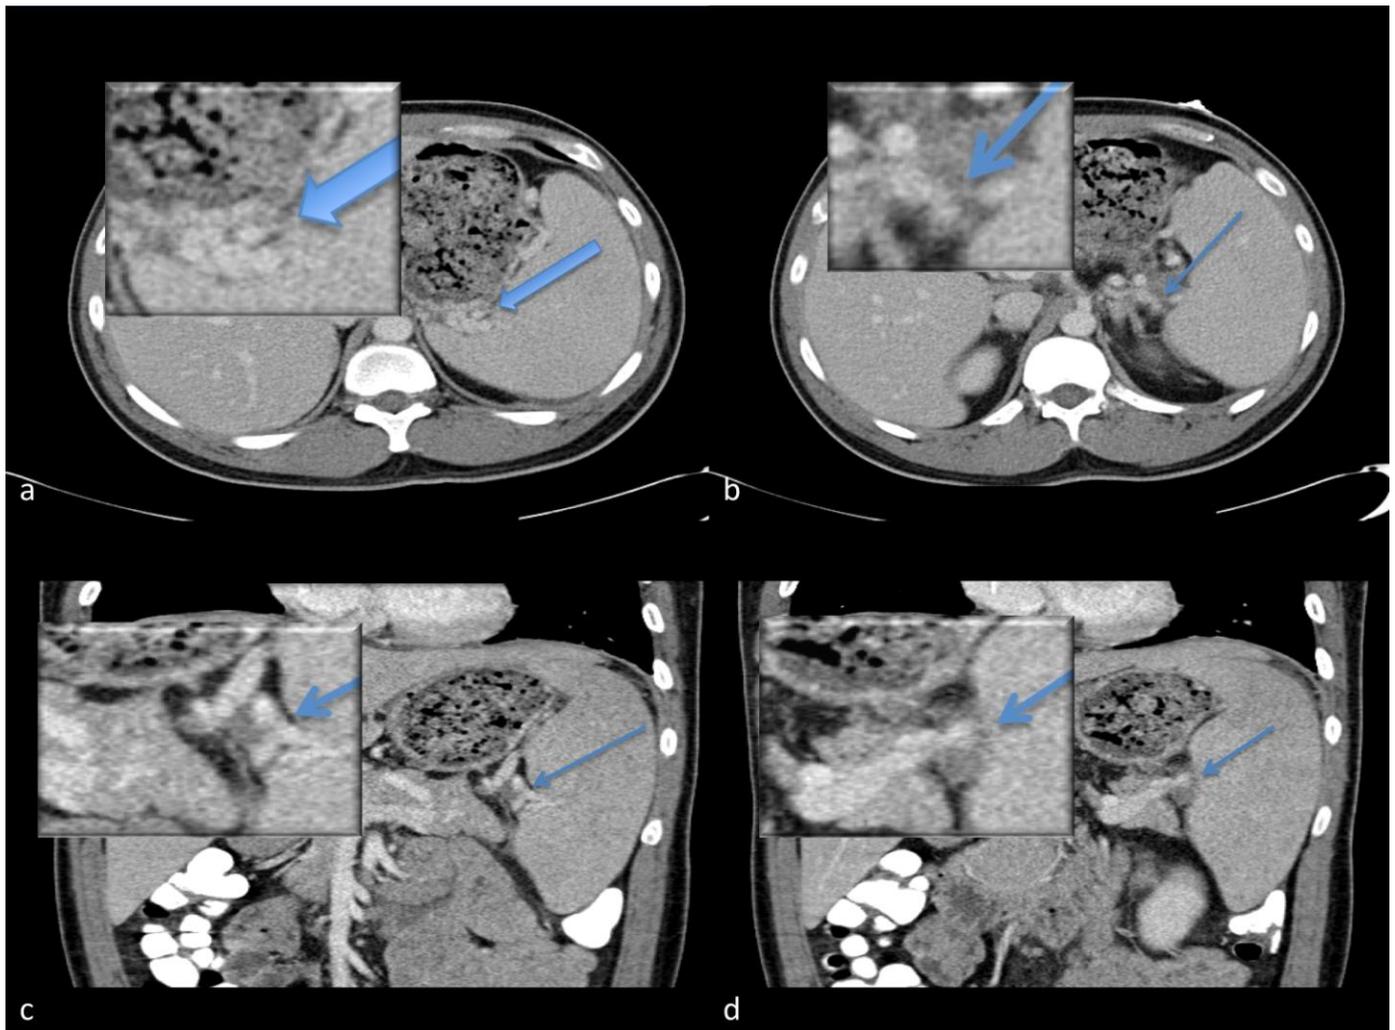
34 year old male with acute onset of hematemesis due to sinistral portal hypertension. Relevant CT scan findings in Portal Venous Phase: Varices (arrow) (a). Soft tissue thickening in splenic hilum (arrow) (b). Splenic vein incomplete filling (arrow) (c, d) on coronal view. Areas of suspected pathology magnified in insert of each corresponding image. (Protocol: Siemens Sensation 64, 3mm slice thickness, 120 kVp 369 mA, Omnipaque 350, 120 cc)
